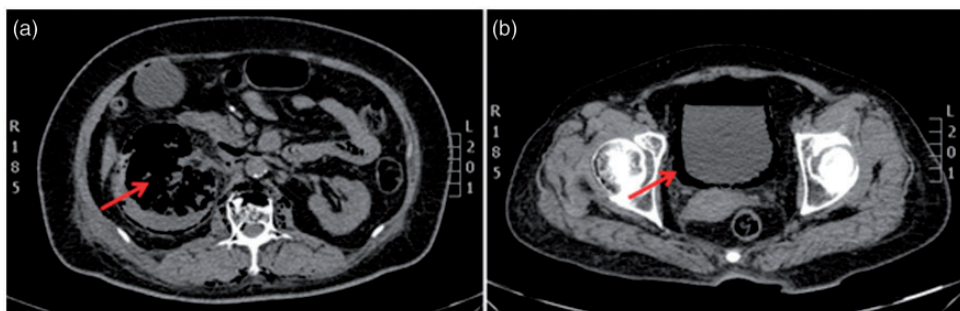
Nonenhanced computed tomography (CT) images showing gas in the right kidney (red arrows) (a) and in the urinary bladder wall (red arrows) (b).
